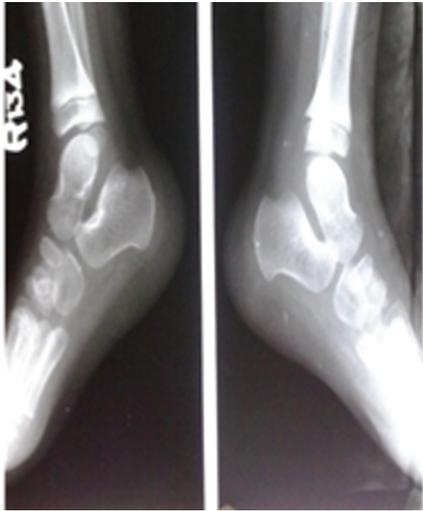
X-ray Showing Bilateral Dislocation of Talo-tibial and Talo-calcaneal Joint
